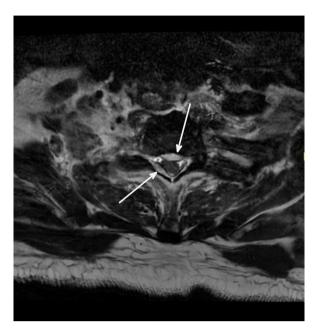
MRI C-Spine: Axial and Coronal view - Ventrally, the abscess extends up to at least the C4-C5 level. Dorsally, the abscess extends up to at least the C7 level. There is additional dural-based and epidural enhancement that effaces CSF surrounding the cord up until the C3-C4 level.Imaging appearance of severe central canal stenosis from C3-C4 down to cervicothoracic junction.
